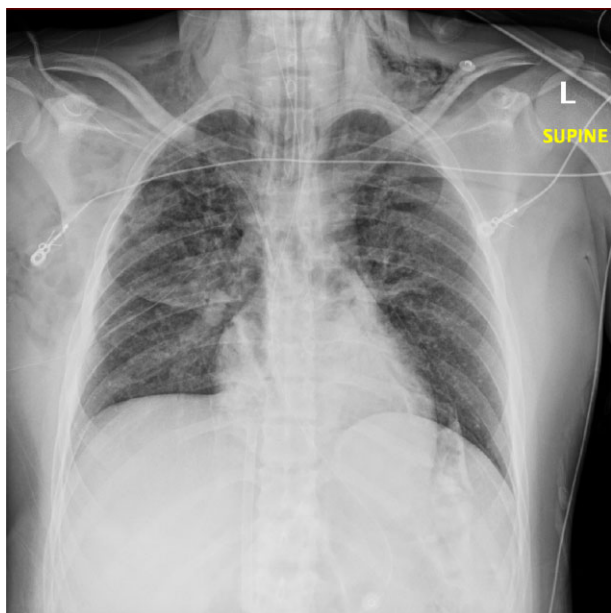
Widespread bilateral interstitial lung markings on chest X-ray.
